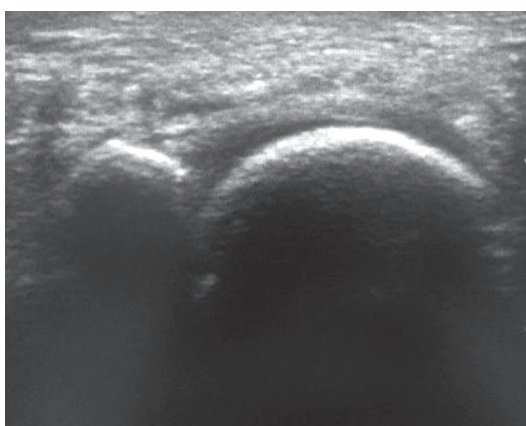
Sonographic scan showing absent plantar plate tear graded G0
